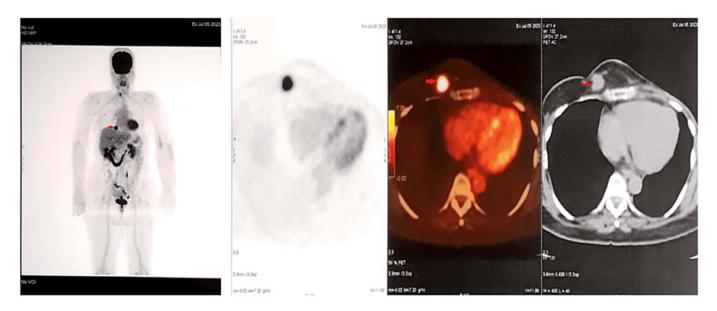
Pet scan showing prepectoral nodular hypermetabolism located in the right prepectoral region (SUV max 12,94), with no evidence of distant metastasis.
